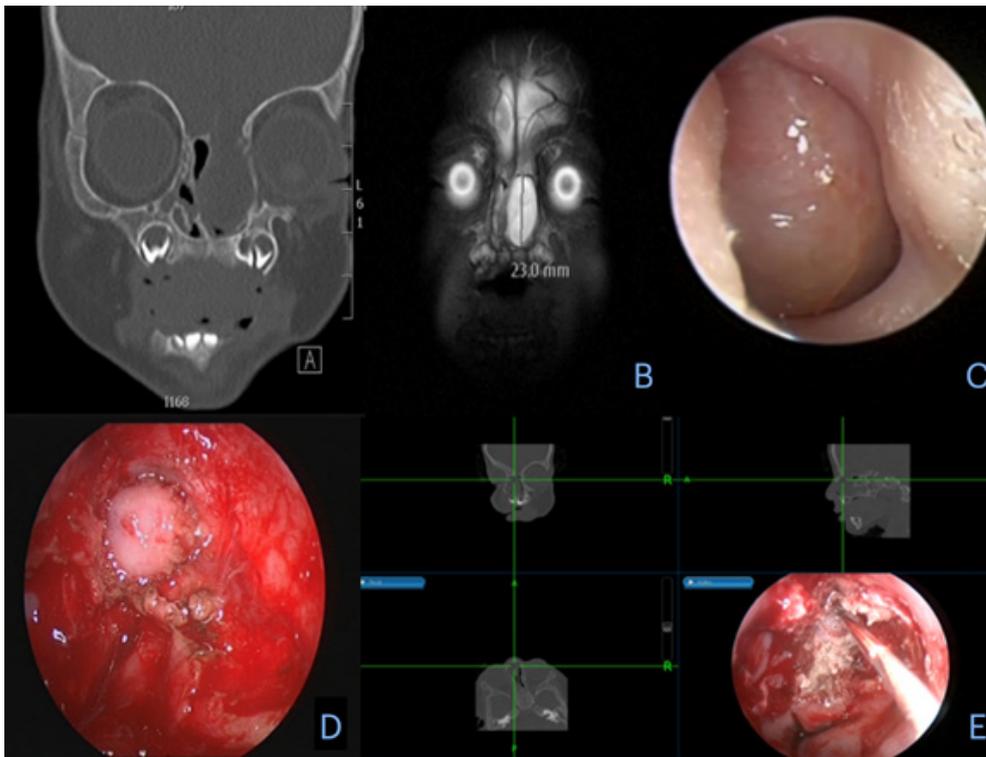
(A, B): Coronal CT and MRI scans of a left ethmoid encephalocele, (C): Endoscopic view of meningocele sac filling the left nasal cavity. (D): Intra-op view of the reconstructed skull base defect with free graft, (E): Image guided surgery for accurate placement of graft and skull base reconstruction.
